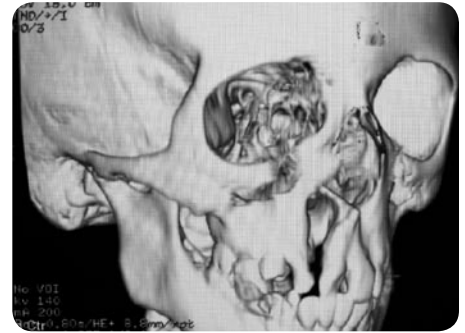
CT showing the cleft.
